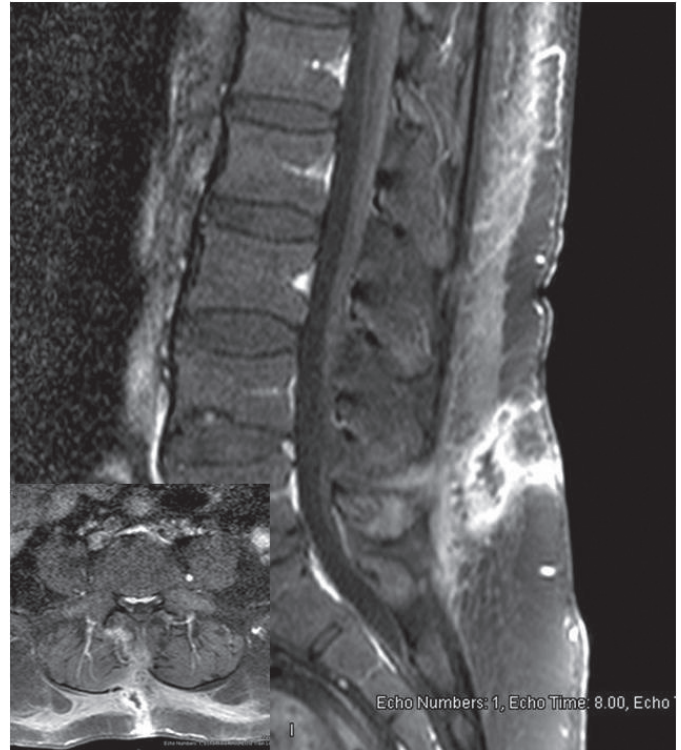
The figure shows a superficial SSI in the T1-weighted contrast MRI of a patient who underwent L5-S1 discectomy SSI: Surgical site infection, MRI: Magnetic resonance imaging
